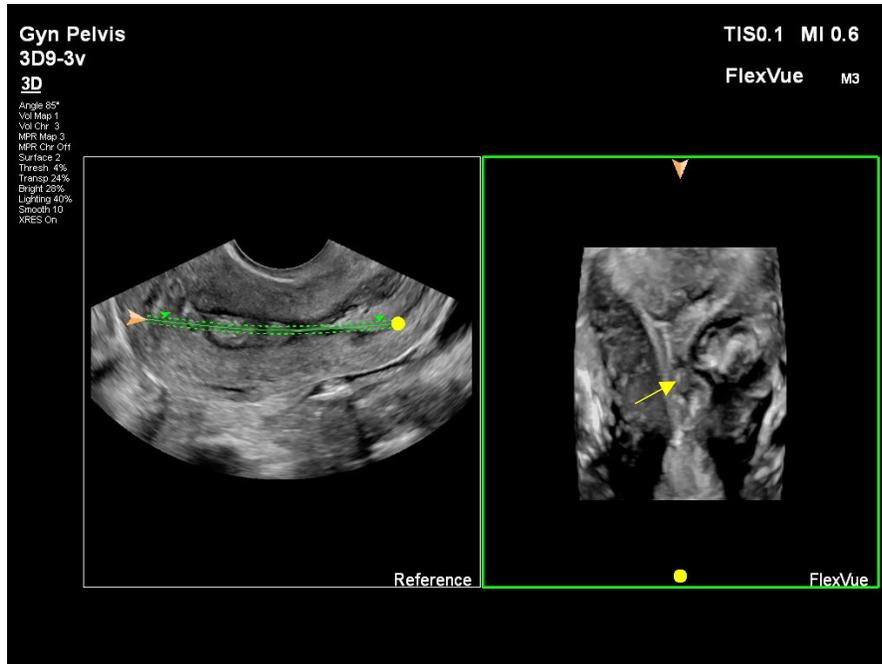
Using ultrasound tomography mode / flexvue on Epiq Elite Phillips® machine. Selective slide from the 3D volume, is represented, and the P3 is detected with precision (yellow arrow), the 3D image is rotated to the right in order to see better the left ostium and cornual myometrium.
